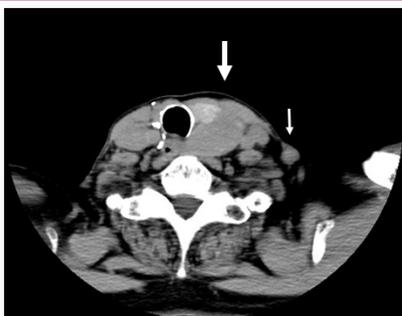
Computed tomography findings prior to second operation. Enlargement of left lobe of the thyroid was noted (arrow). Swelling of left cervical lymph node was noted (small arrow).
